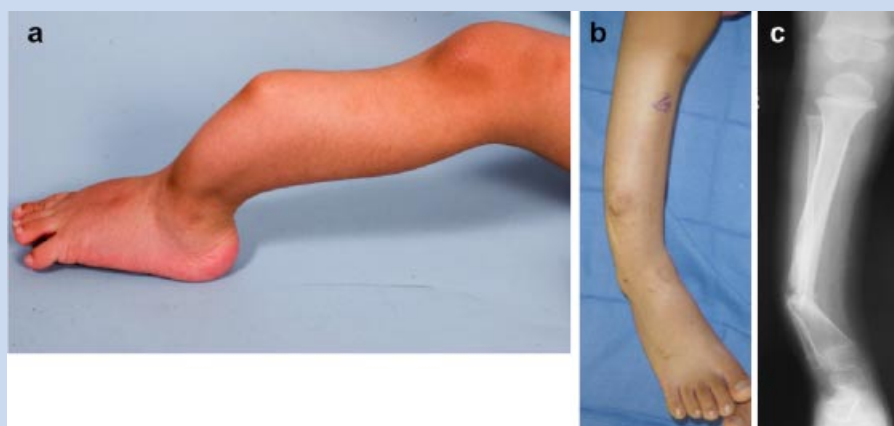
a: Anterolateral bowing of the lower leg of a child with NF1 prior to fracture. b: Photograph of the leg of a child with NF1 with tibial pseudarthrosis. c: Radiograph of the affected leg pictured in [b].
